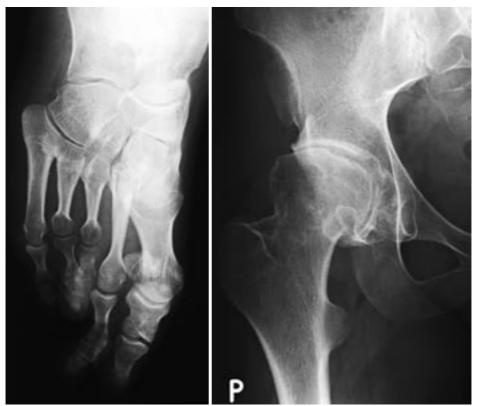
X-ray of the right foot at the age Fig. 2. X-ray of the right hip, 28 years. The lower portion of 28 years – hypoplastic/dysplastic 3rd of the ilia is short and broad. Marked narrowing of all and 4th metatarsals.
